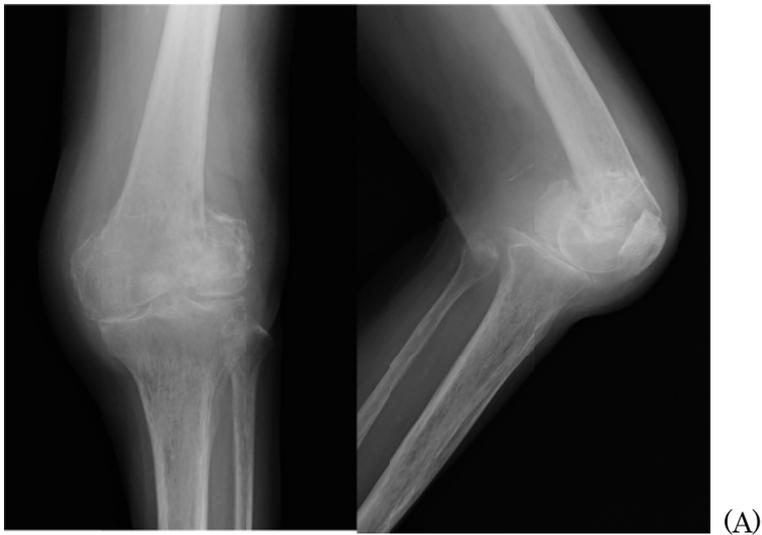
(A) Radiographs at 4 months after injury showed abortive conservative treatment: femoral supracondylar and intercondylar nonunion with considerable bony defects. (B) The knee joint was severely deformed posteriorly and swollen due to synovitis.
